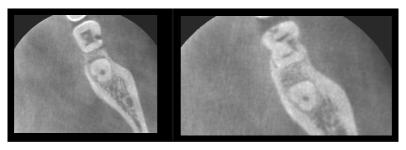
CBCT scan showing buccal resorption tooth 36
